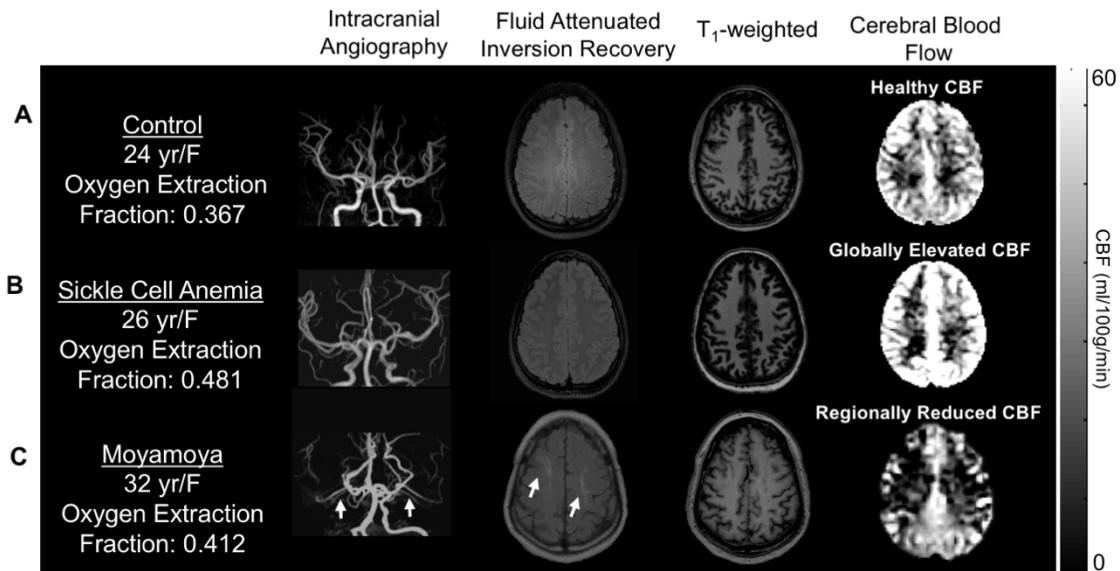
Structural, CBF, and OEF imaging. (A) A healthy control participant with a normal OEF, and normal findings on structural and CBF imaging. (B) A participant with sickle cell anemia (SCA) and (C) moyamoya. The participant with SCA demonstrates elevated CBF in the setting of decreased oxygen carrying capacity of hemoglobin and increased OEF (OEF=0.481). The participant with bilateral moyamoya with lenticulostriate collaterals (white arrows on intracranial angiography), demonstrates right and left anterior and middle cerebral artery territory infarcts seen on FLAIR, bilateral anterior-territory hypoperfusion, and globally elevated OEF (OEF=0.412) relative to control data.
